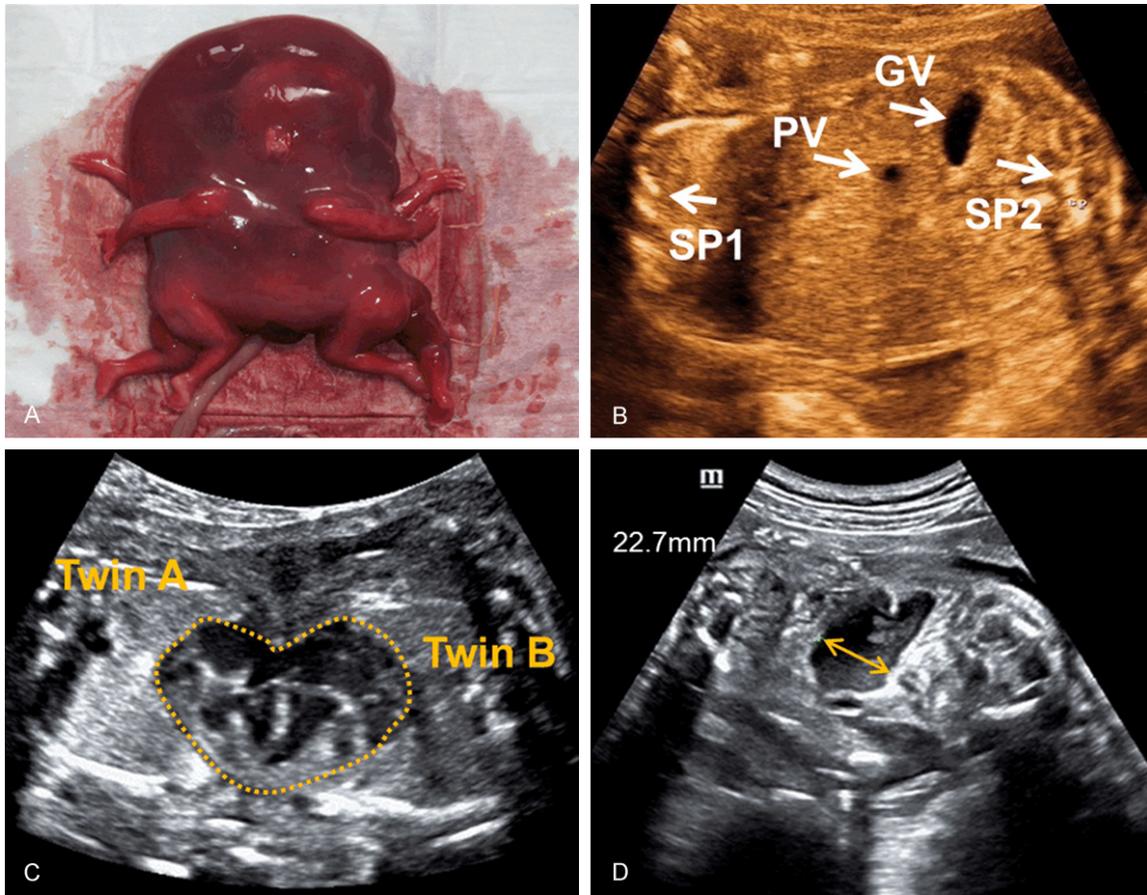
Image and sonography of the thoracopagus twin. A. Twins were joined from upper thorax to abdomen. B. SP Arrow: spinal; SB Arrow: stomach bubbles; PV Arrow: portal vein. C. The shared heart shows multi-malformation. D. Intestinal expansion shows a maximum diameter (Arrow) of 22.7 mm.
